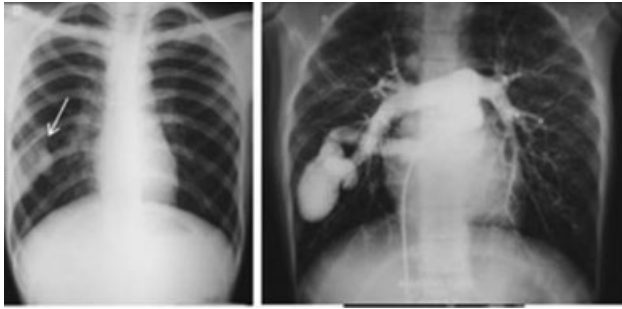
CXR in this adolescent showed a round density to the right and behind right hilum (*arrow*). A nodal mass or a vascular lesion was suspected. CT showed this to be a pulmonary venous angioma (*arrowhead*). CT, computed tomography.
